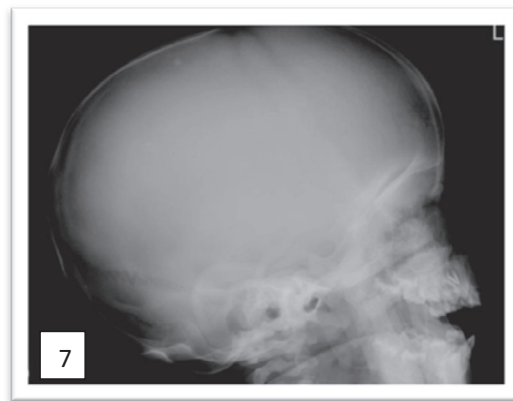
Skull X-ray of the proband reported as normal
